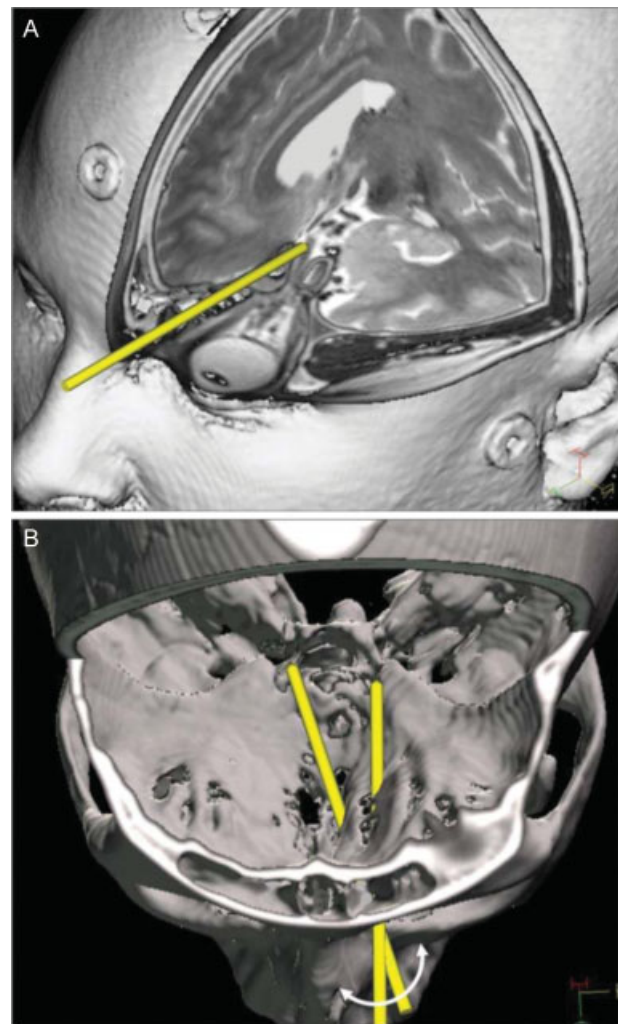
TONES surgery may also involve a precanthal incision which is suited to access the central (interorbital) skull base. A scaled representation of a 4 mm endoscope inserted through a precanthal incision is shown on a MRI/CT fusion in pane (A). The central skull base accessible through the precanthal incision is the area bound between the wands in pane (B). (Adapted from Moe et al⁷⁶ and reproduced with permission from Wiley and Sons.)
